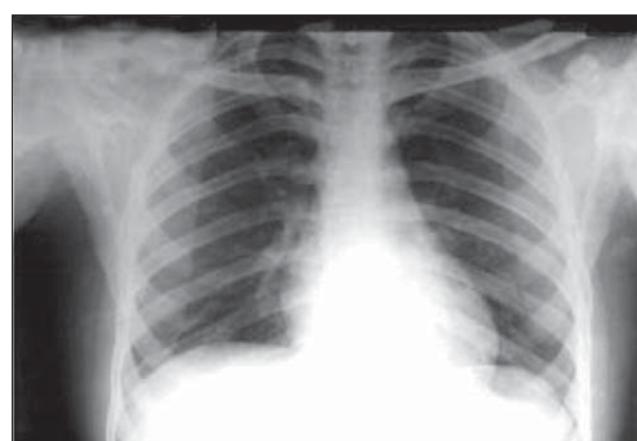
X-ray chest one month after the removal of the denture
